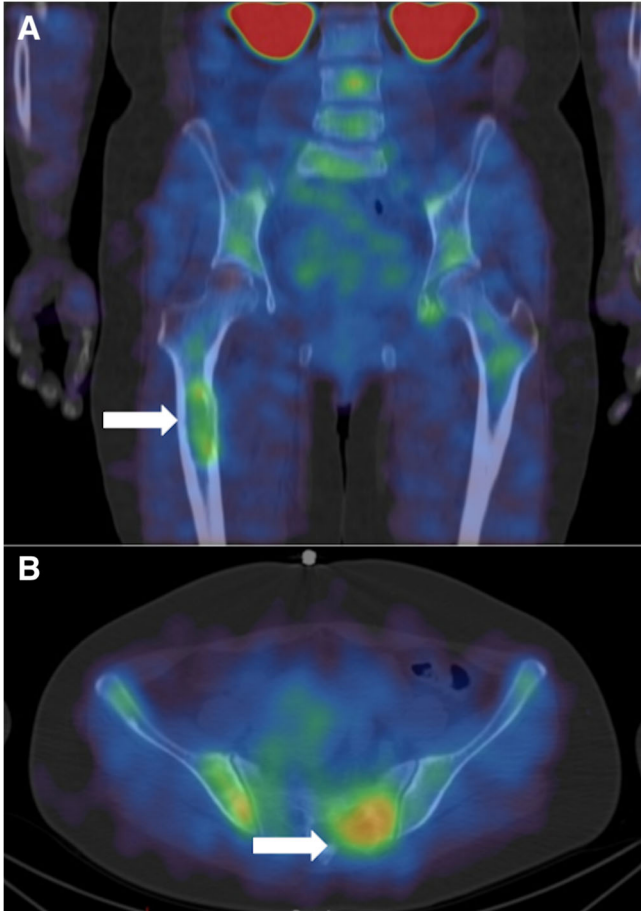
Coronal (A) and axial (B)  $^{99m}\text{Tc}$ -NM-01 SPECT/CT images of a patient with skeletal metastases (arrows) demonstrating PD-L1 expression.
